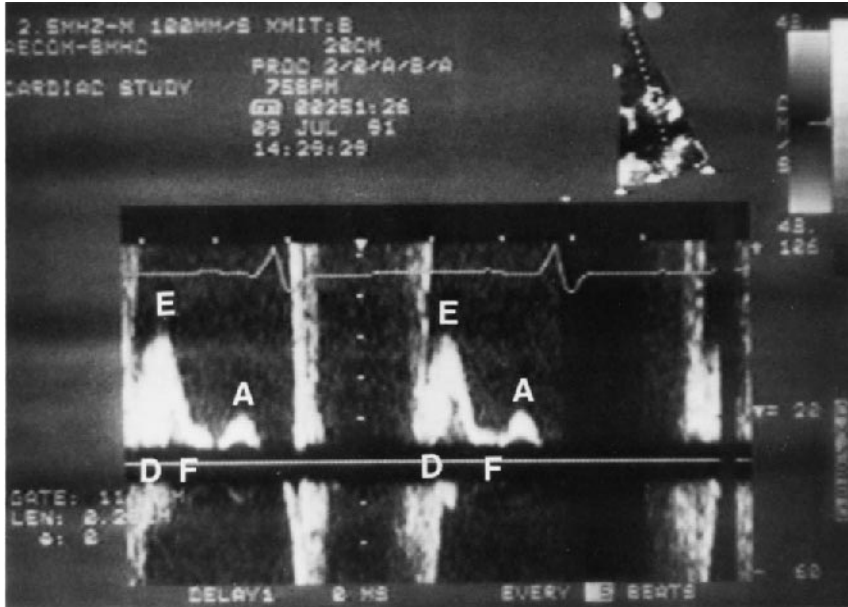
LV diastolic waveforms obtained with pulsed Doppler echocardiography in an elderly patient with dilated cardiomyopathy show increased flow velocity of early peak (E), fast deceleration of early diastolic flow velocity from (from E to F), shortening of early diastolic filling component from (D to F) with visible diastasis, and decreased maximal velocity of the late peak as a result of atrial systole (A).
